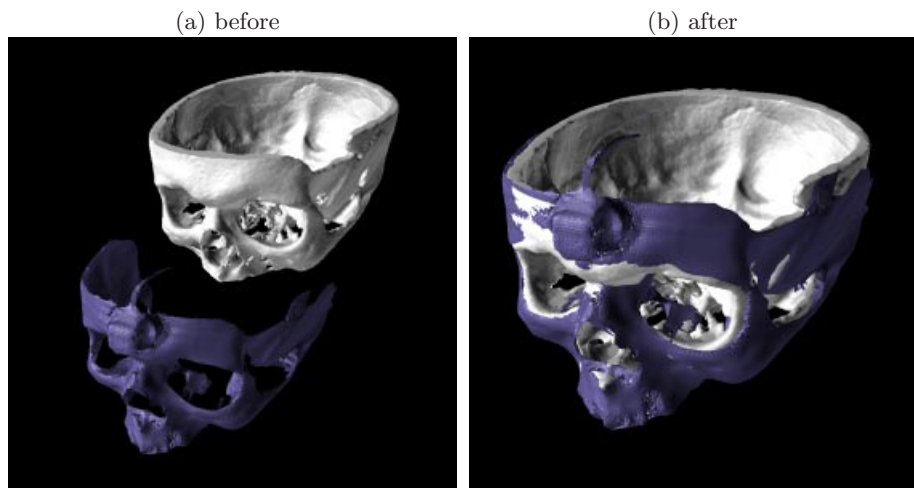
Registration of the volume-rendered CT data and the laserscanned surface of the skull model.
